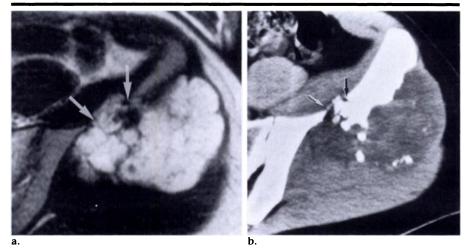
Secondary chondrosarcoma arising in osteochondroma. (a) Axial T2-weighted MR image (SE 1,800/70). (b) CT image obtained with soft-tissue window. Both the MR and the CT images demonstrate the destruction of the medial aspect of the iliac wing (arrows). The lobulated nature of the mass suggests a chondroid origin. The relative low attenuation of the mass and the calcifications on the CT scan are typical of a cartilage lesion.
